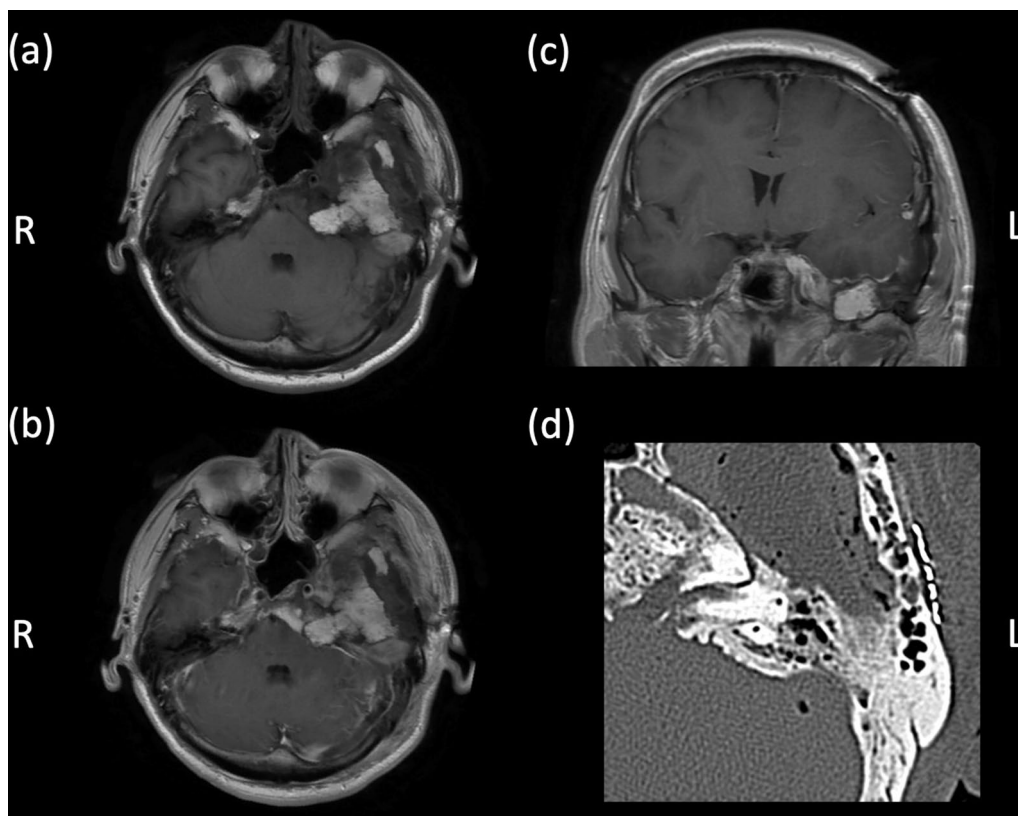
Postoperative images of the cavernous sinus tumor within a week after surgery. a Axial view of T1-weighted brain MRI. b Axial view of gadolinium-enhanced T1-weighted brain MRI demonstrates that posterior part of the tumor removed and fat tissue packed. c Coronal view of gadolinium-enhanced T1-weighted MRI. d Axial view of CT demonstrates that thickened petrosal bone resected and internal auditory meatus opened
